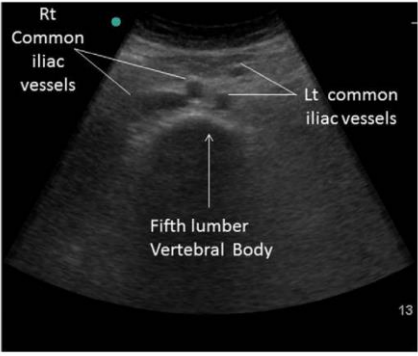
Transverse ultrasound image showing the body of fifth lumbar vertebra with bilateral common iliac vessels.
